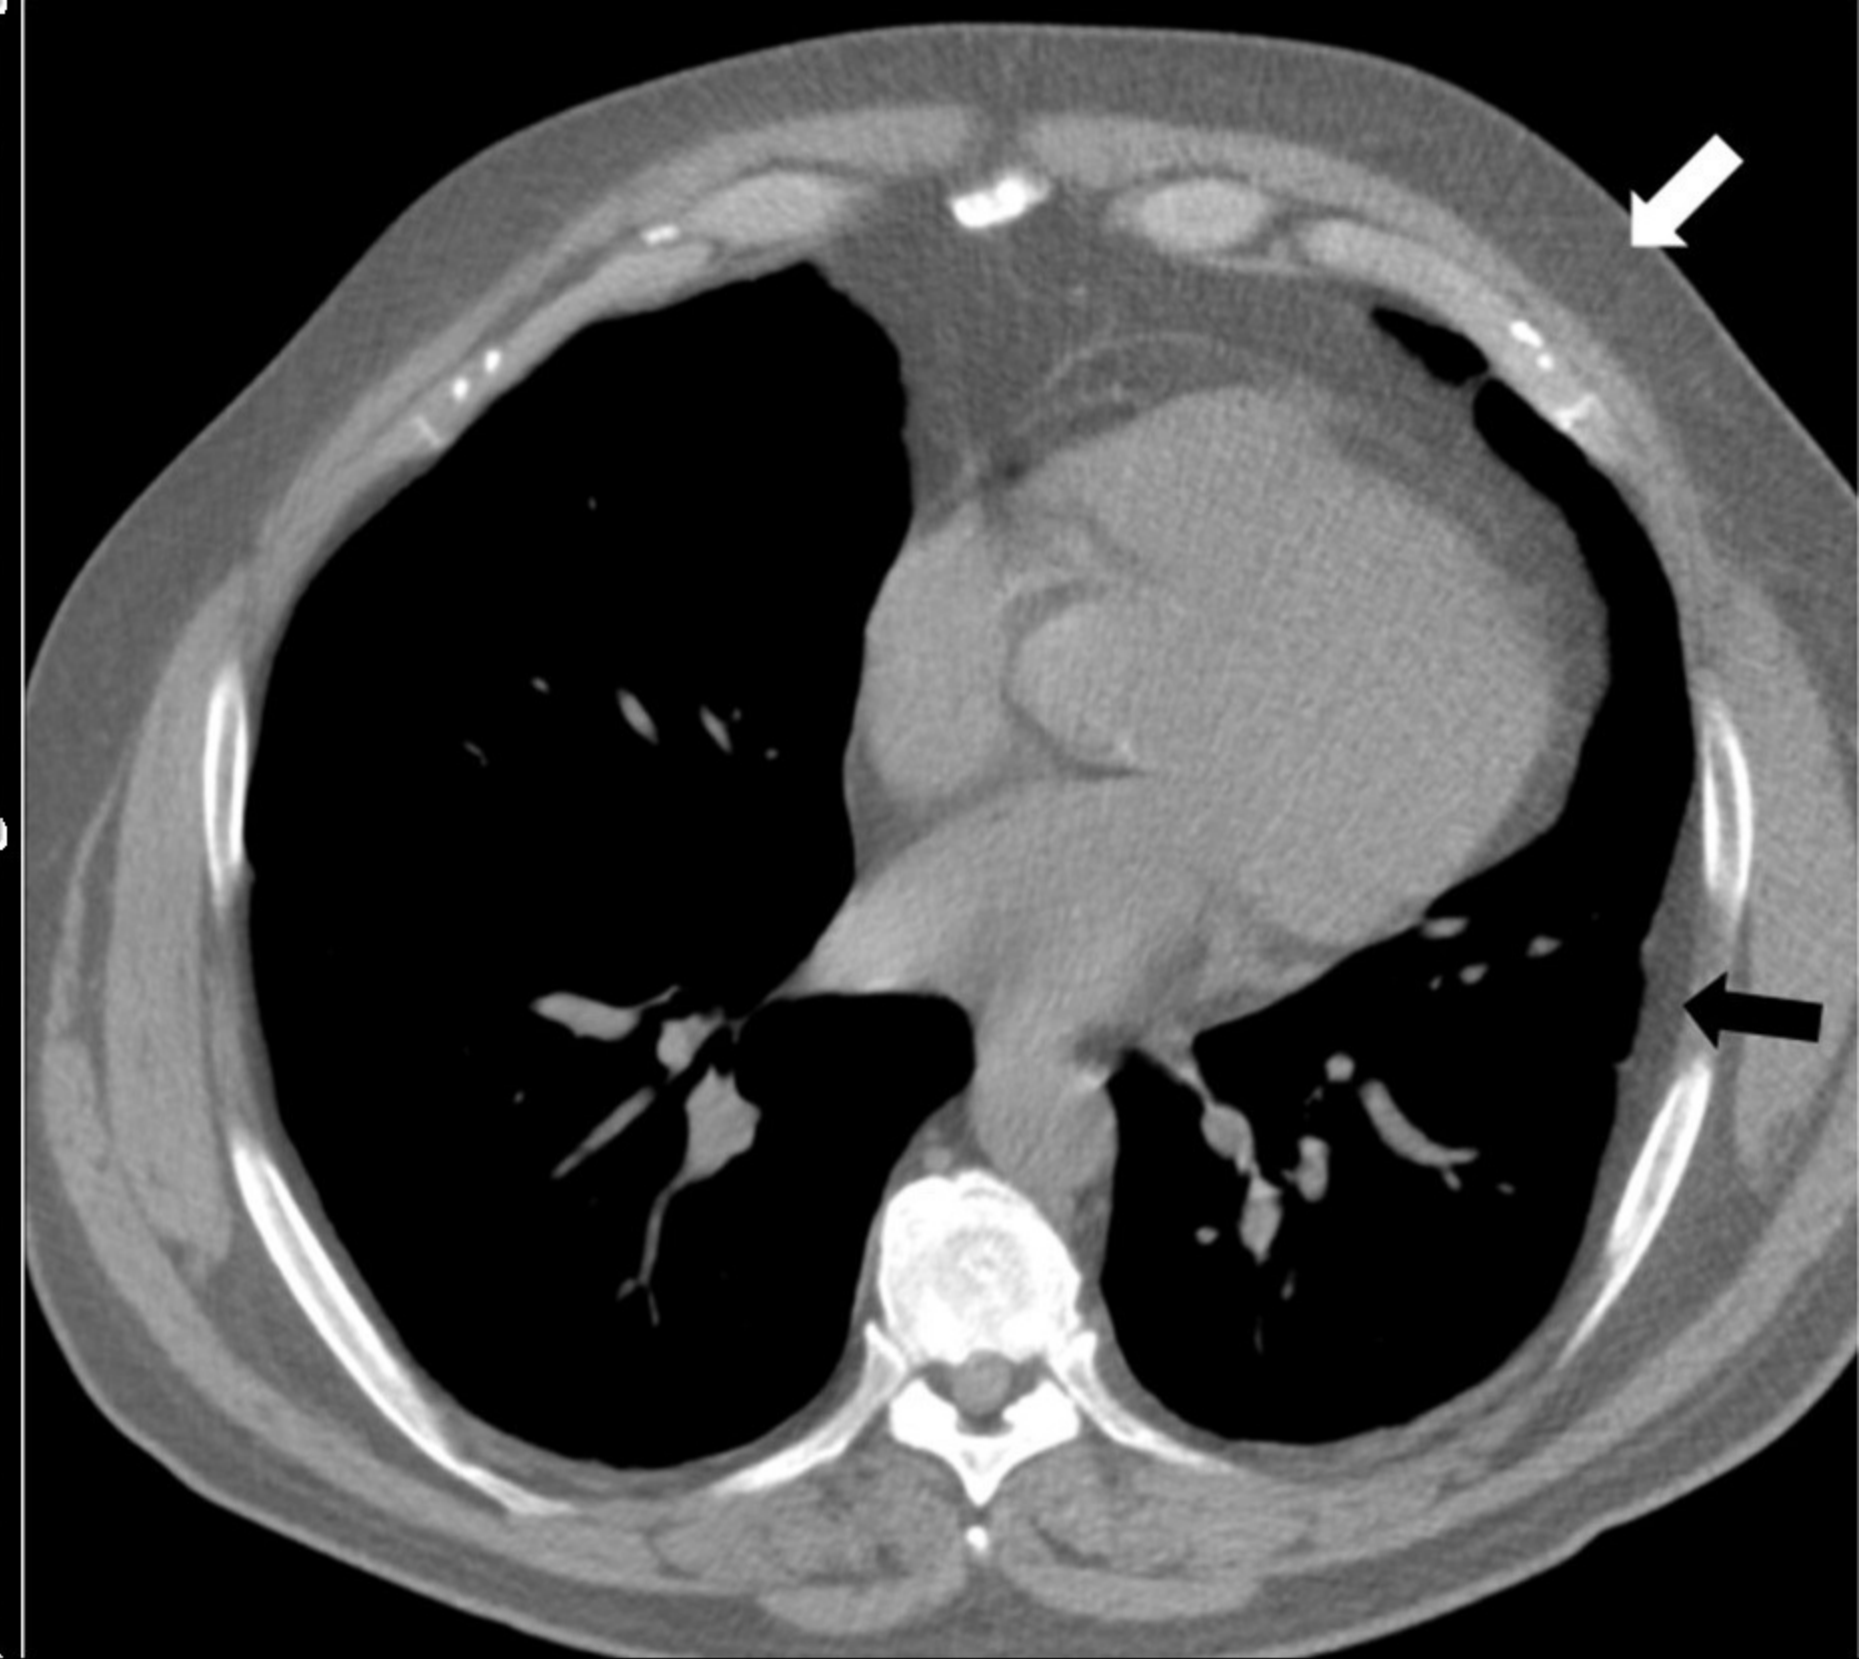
CT scan of the same patient from Figure 8. Note attenuation of pleural thickening (black arrows) similar to subcutaneous fat (white arrow), showing fat attenuation.
